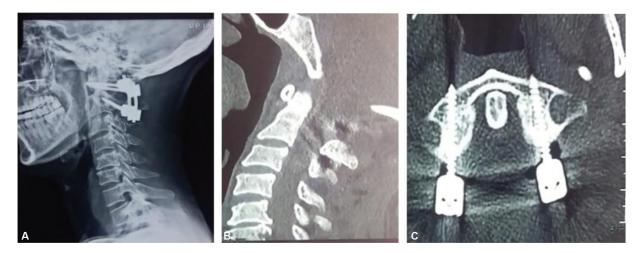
Postoperative (A) X-ray craniovertebral junction (CVJ) showing bilateral C1 lateral mass and C2 pedicle screw fixation. (B) Noncontrast computed tomography (CT) CVJ showing reduction of atlantoaxial dislocation (AAD) and widened spinal canal (C) bilateral C1 lateral mass screw.
